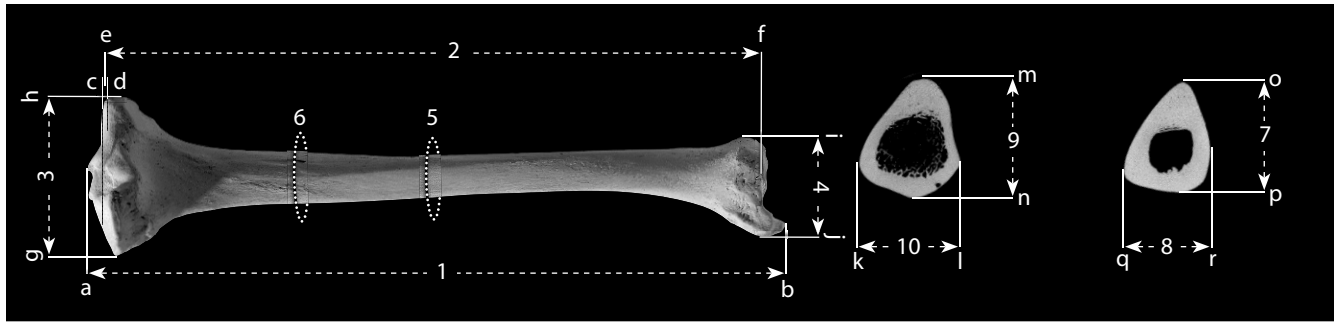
Tibial measurements. One-fourth (bone) and one-half (CT scan) natural size.
